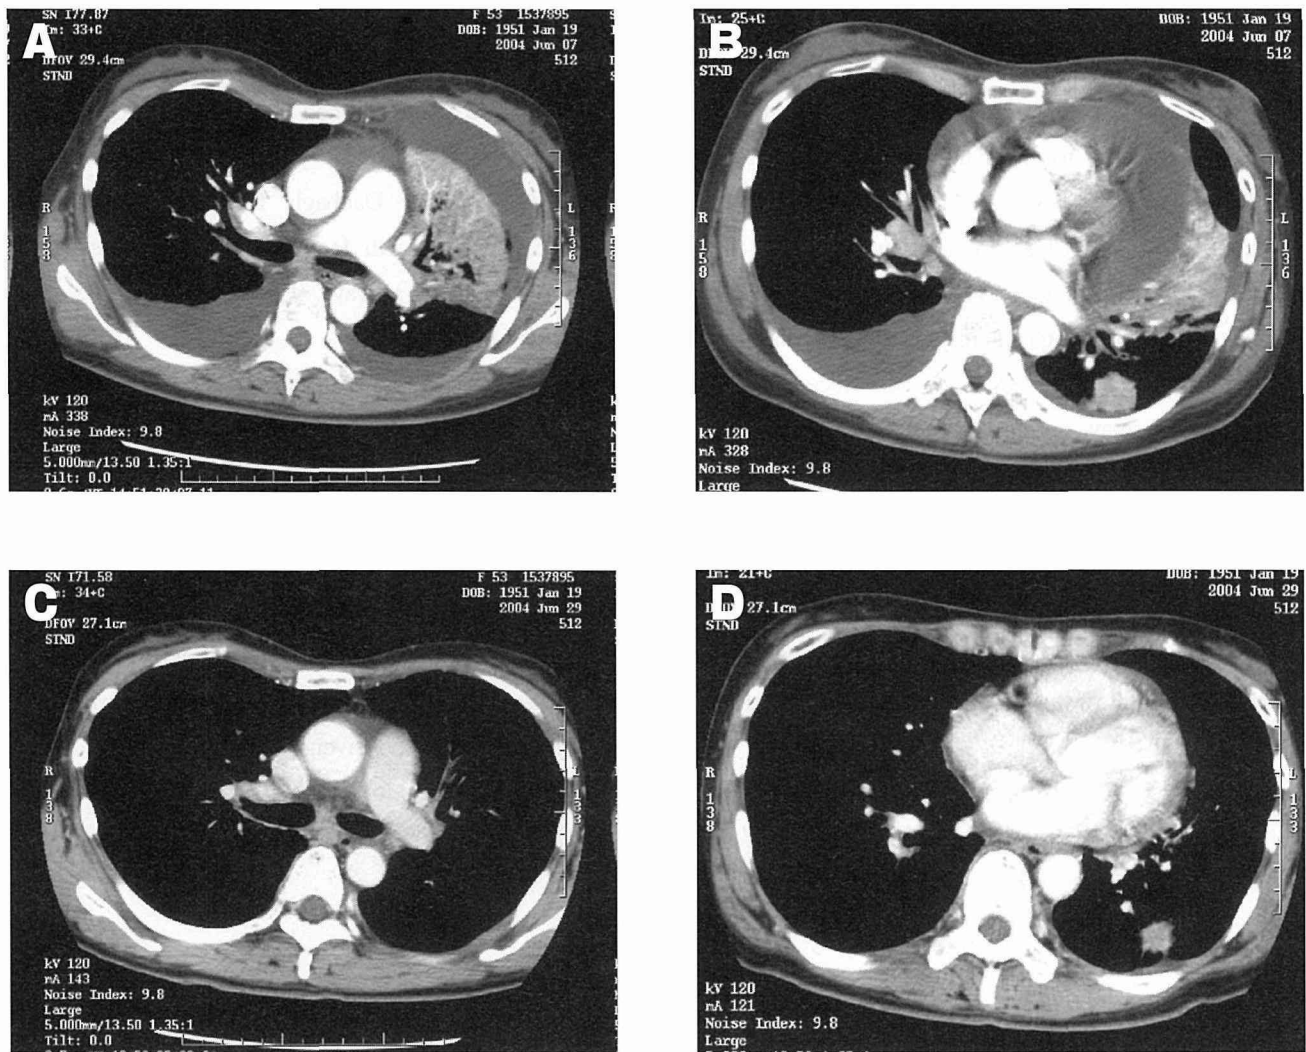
Contrast-enhanced CT of the chest.
